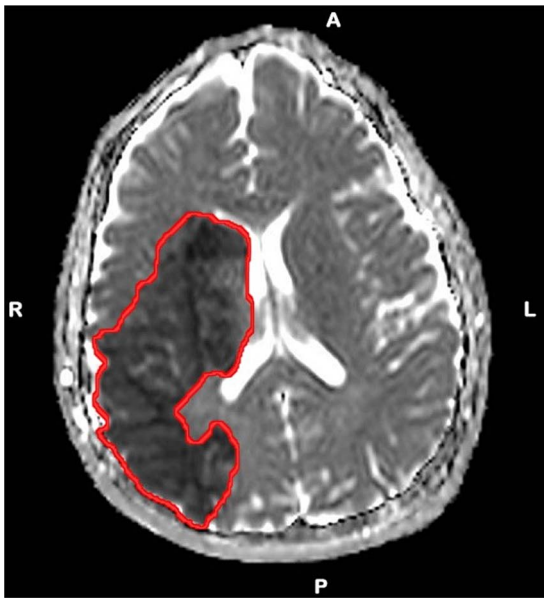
MRI demonstrates an apparent diffusion coefficient map of the brain, revealing ischemia in the right fronto-parietal-temporal lobes.
